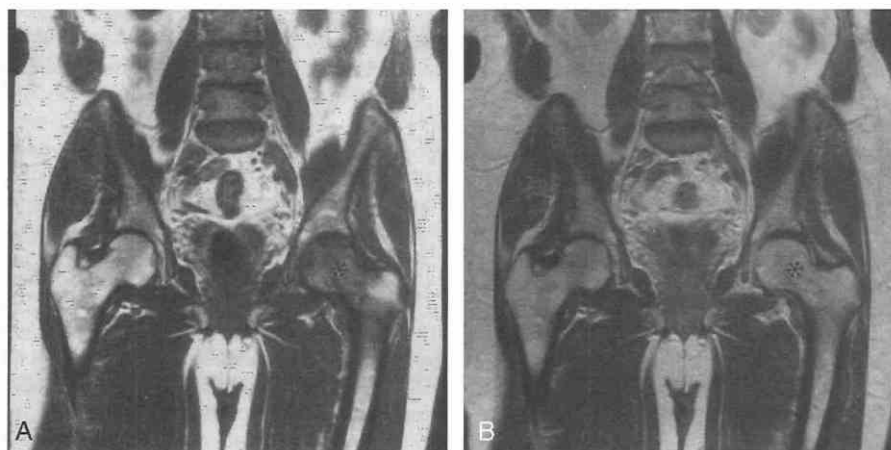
Transient osteoporosis of the hip in a 77-year-old man with a 3-month history of left hip pain. Coronal T1-weighted MR images before (A) and after (B) intravenous gadolinium injection show marrow replacement diffusely in the left femoral head and neck (asterisk), which enhances with contrast material to become isointense to normal marrow (asterisk), respectively. No focal nonenhancing areas are seen, as would be expected with avascular necrosis. Long-repetition-time (TR) MR images (not shown) revealed increased intensity in the left femoral head and neck, consistent with edema and small joint effusion. Patient symptoms and MRI changes resolved over the next 3 months without treatment.
